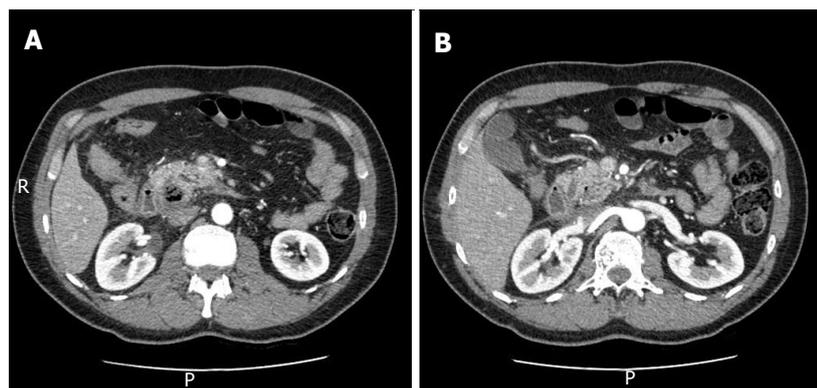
Abdominal contrast-enhanced computed tomography showing the presence of gas within the pancreatic head. A: Suggestive of focal emphysematous pancreatitis; B: Oedema of the duodenum. There was no free air suggestive of perforation.
